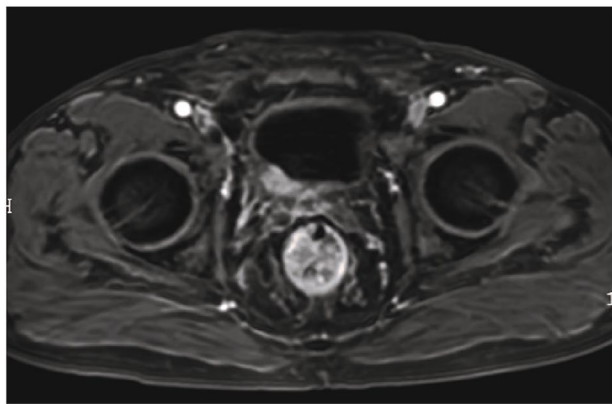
Enhanced pelvic MRI image of the bladder. Enhanced pelvic MRI revealed a rough bladder wall and thickening enhanced right posterior bladder wall
